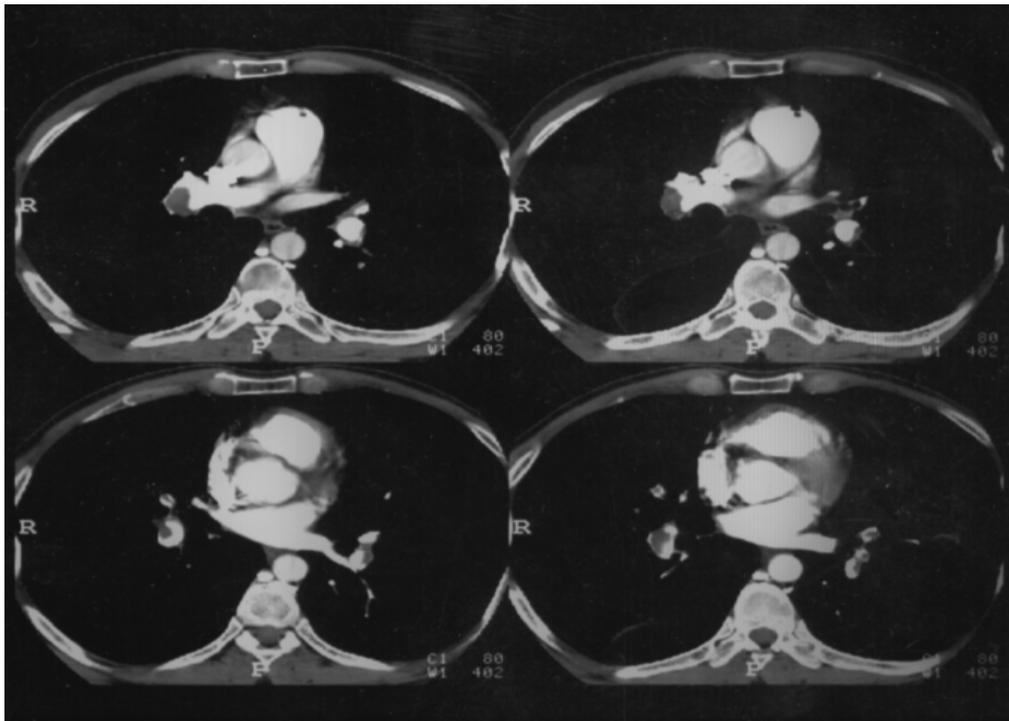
Multiple partially occlusive intra vascular filling defect in the pulmonary trunk & main pulmonary arteries, lobar & segmental arteries producing the "signet-ring, or polo mint, or rim sign" as viewed on axial CT section.
